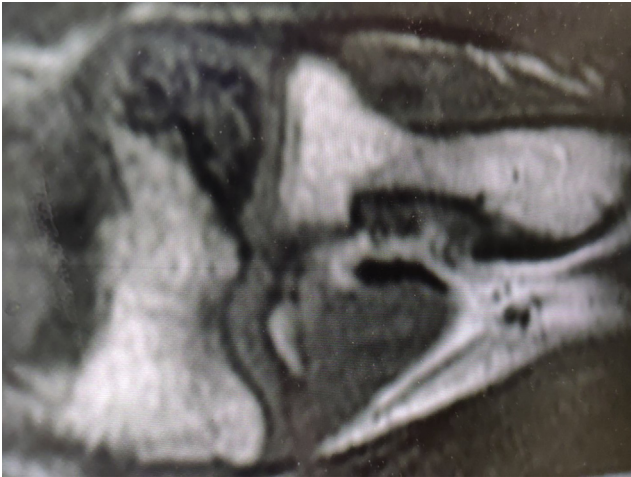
MRI demonstrating avascular necrosis of the humeral capitellum.
